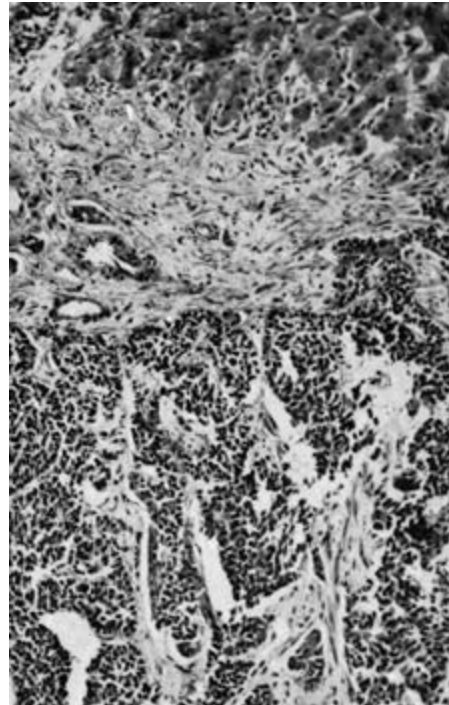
Anaplastic secondary carcinoma of the liver. The tumour is composed of sheets of undifferentiated malignant cells. Normal liver cells are seen at the top. There was a small bronchial primary growth which was not revealed by chest X-ray. (H & E, ×110.)
